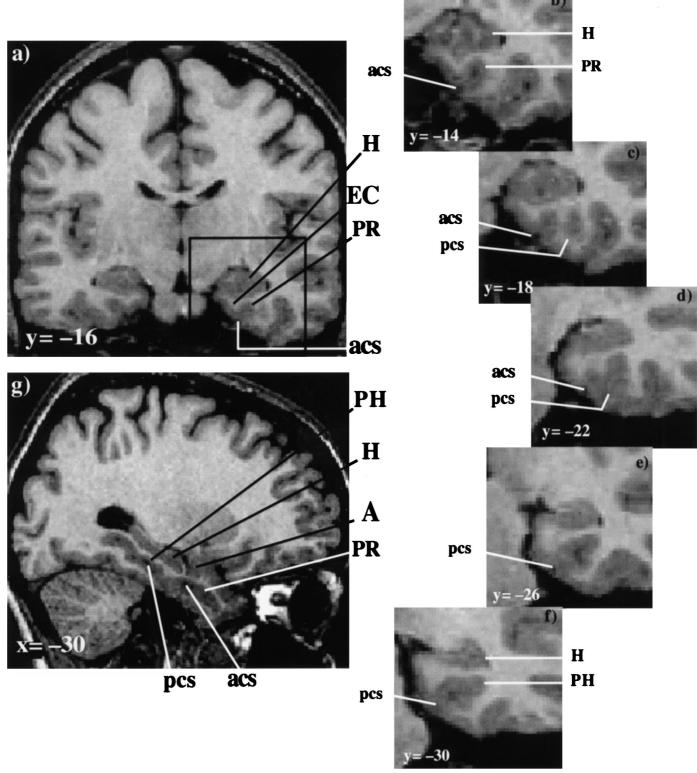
This figure shows how the anterior collateral sulcus ends while another nearby sulcus, the posterior collateral sulcus, forms and runs posteriorily until the end of the hippocampus. (a) is a coronal section of a normal subject's MRI at the stereotaxic level y = -16 to show the hippocampus, entorhinal cortex, perirhinal cortex and the anterior collateral sulcus. The inset square in (a) represents the part of the brain which is displayed in (b–f) (sections every 4 mm). The anterior collateral sulcus is present in (b) and (c) but fades in (d) and disappears in (e). The posterior collateral sulcus appears in (c), lateral to the anterior collateral sulcus and continues until the posterior limit of the hippocampus in (f). This separation of the anterior and posterior collateral sulcus can be seen in the MRIs of the patients with lesions, and it is especially clear in patient PV. In (g) a sagittal section (x = -30) shows that the anterior and posterior parts of the collateral sulcus are divided. *Abbreviations*: H: hippocampus, A: amygdala, EC: entorhinal cortex, PR: perirhinal cortex, PH: parahippocampal cortex, as: anterior collateral sulcus, pcs: posterior collateral sulcus. Coordinates are in the Tailarach and Tournoux [47] stereotaxic space: y refers to the mm behind the anterior commissure and x, mm from the midline.
